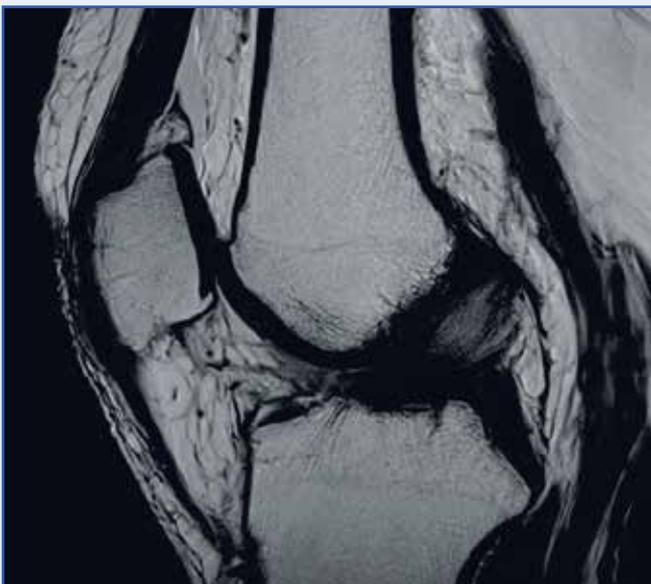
MRI PD sagittal image showing swollen hyperintense ACL suggesting mucoid degeneration
